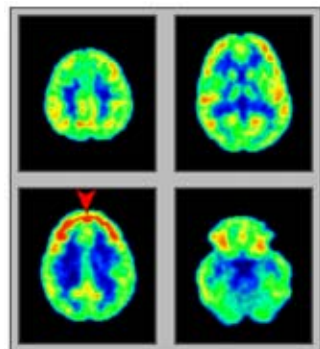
FDG (fluorodeoxyglucose) labeled with the  $^{18}\text{F}$  fluorine isotope
